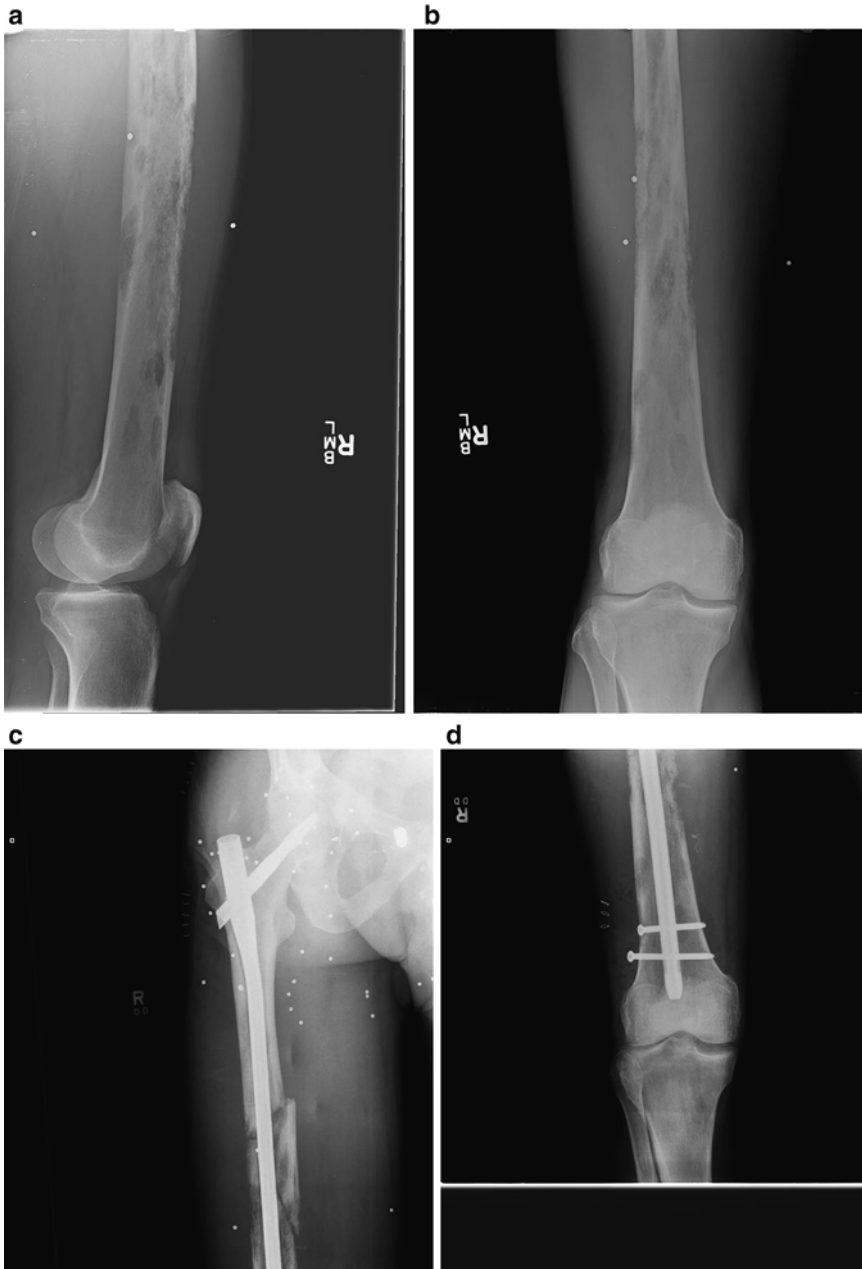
(a, b) Fifty-seven year-old man presented with severe left lower extremity pain and abnormal femoral radiographic findings. He was found to have widespread metastasis, with unknown primary. (c, d) He underwent biopsy and stabilization with cephalomedullary nail as he
